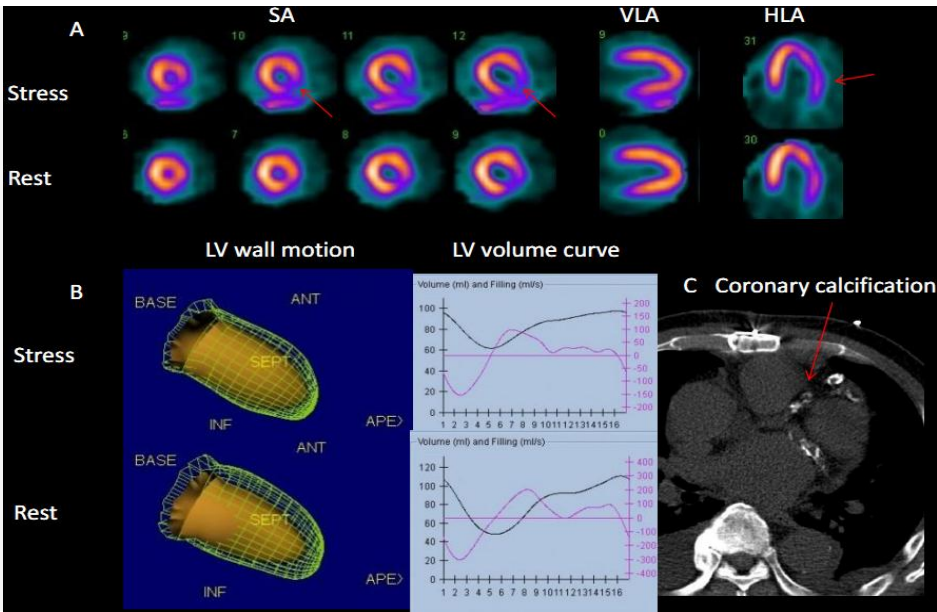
Coronary calcification and ischemia. A 71 year-old male with myocardial ischemia. A) The stress myocardial perfusion imaging demonstrated inferolateral ischemia in the SPECT images. SA short axis, VLA vertical long axis, HLA horizontal long axis. B) Quantitative gated SPECT showed decreased inferolateral wall motion and ejection fraction on the stress image. C) Coronary calcification on the middle portion of the left circumflex coronary artery and the left descending coronary artery was observed.
